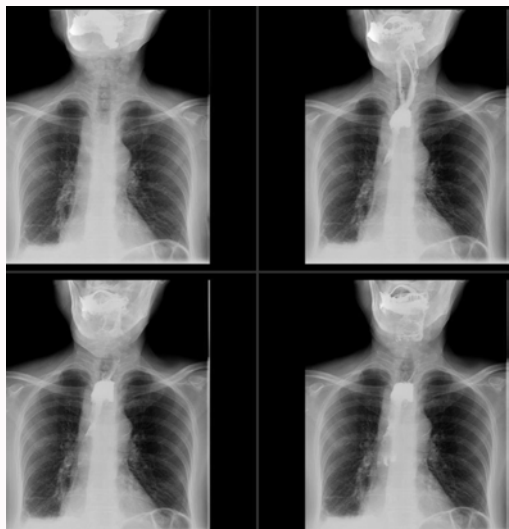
The esophagus shifted to the right side, in the thoracic section, presumably modeling on external structures, although intramural changes cannot be excluded, with multilevel stenosis of various degrees and dilated sections. The gastroesophageal junction is unobstructed, with good flow of contrast medium into the stomach. Further diagnosis by CT scan is indicated.
